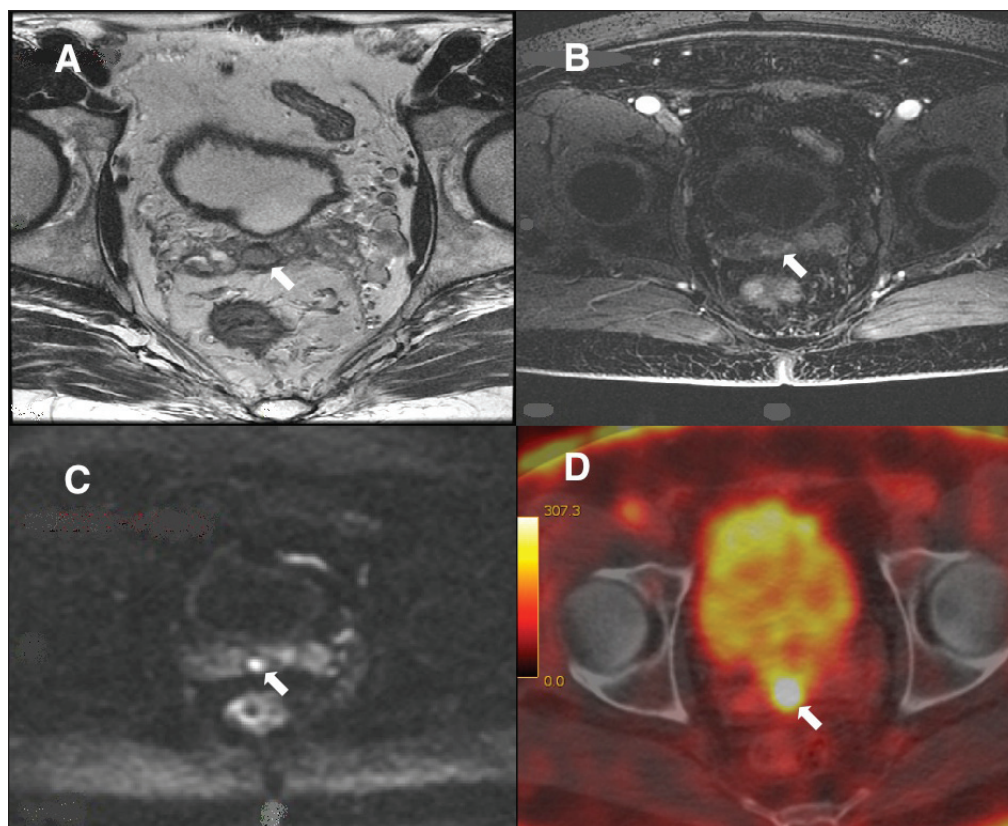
Multiparametric magnetic resonance image and [^{18}F]Fluoro-deoxy-glucose positron-emission tomography (PET) combined with a computed tomography (CT) scan. A: T2-weighted axial image of right seminal vesicle mass (SV) in low signal (arrow). B: Peripheral enhancement of the mass at T1-contrast-enhanced sequence (arrow). C: Nodular hyper-signal of right SV at Diffusion-weighted image (arrow). D: Focus of high activity in area of right SV at [^{18}F]FDG-PET combined with CT-scan (arrow).
